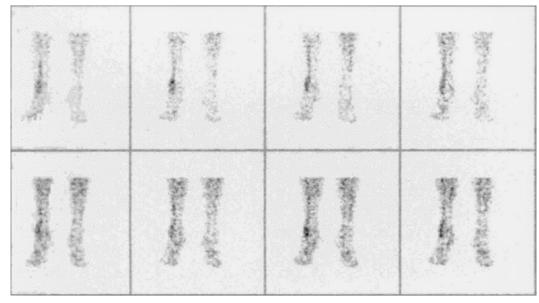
Early phase of ^{99m}Tc-HDP multiphase scintigraphy, depicting hyperaemia of affected muscles secondary to the focal myositis.
